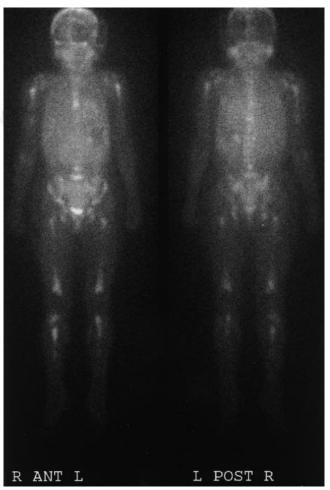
¹²³I-MIBG image of 8-y-old child with widespread relapsed disease that did not respond to chemotherapy. Treatment with 666 MBq/kg (18 mCi/kg) of ¹³¹I-MIBG achieved a complete remission; follow-up ¹²³I-MIBG scintigraphy showed no abnormal uptake.
